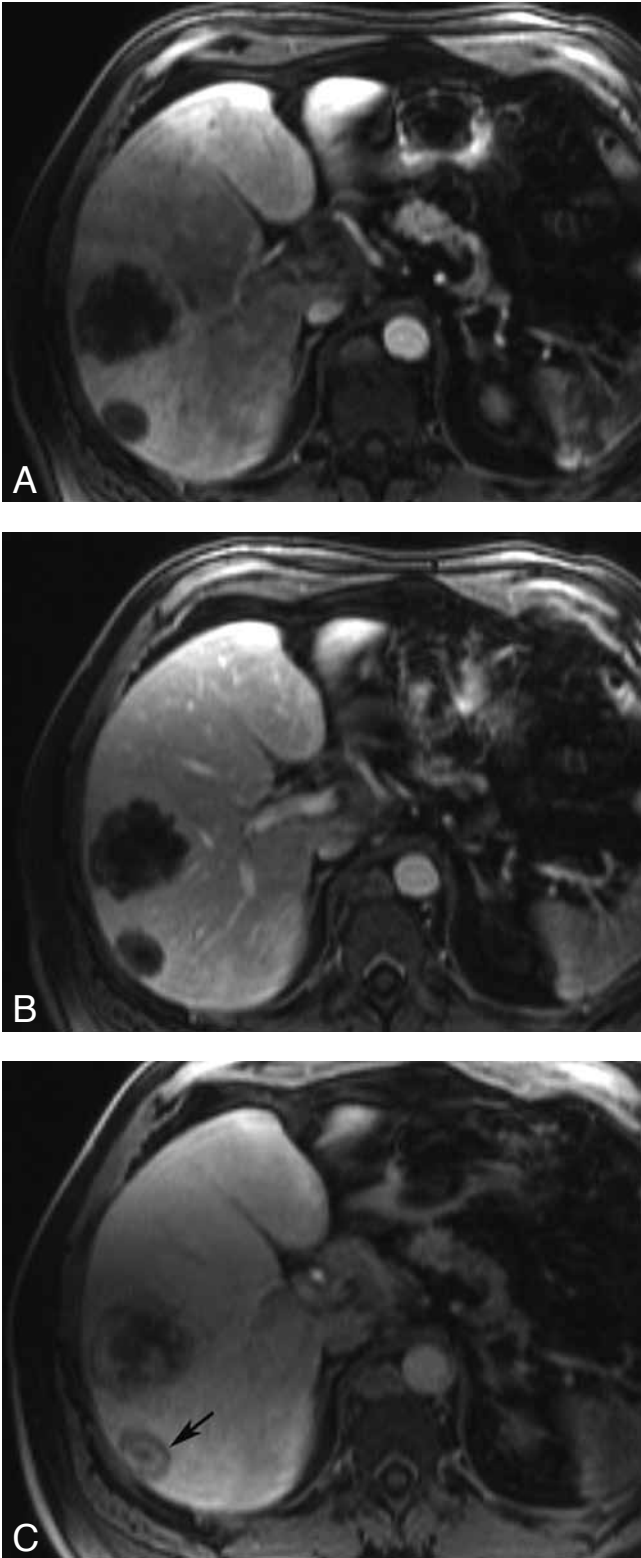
Dynamic gadolinium-enhanced MRI of colon cancer metastasis. A-C Dynamic contrast-enhanced MRI in the arterial (A), venous (B), and equilibrium-phase (C) shows rim enhancement in the venous phase and peripheral wash-out (arrow), which is quite specific for malignancy.
